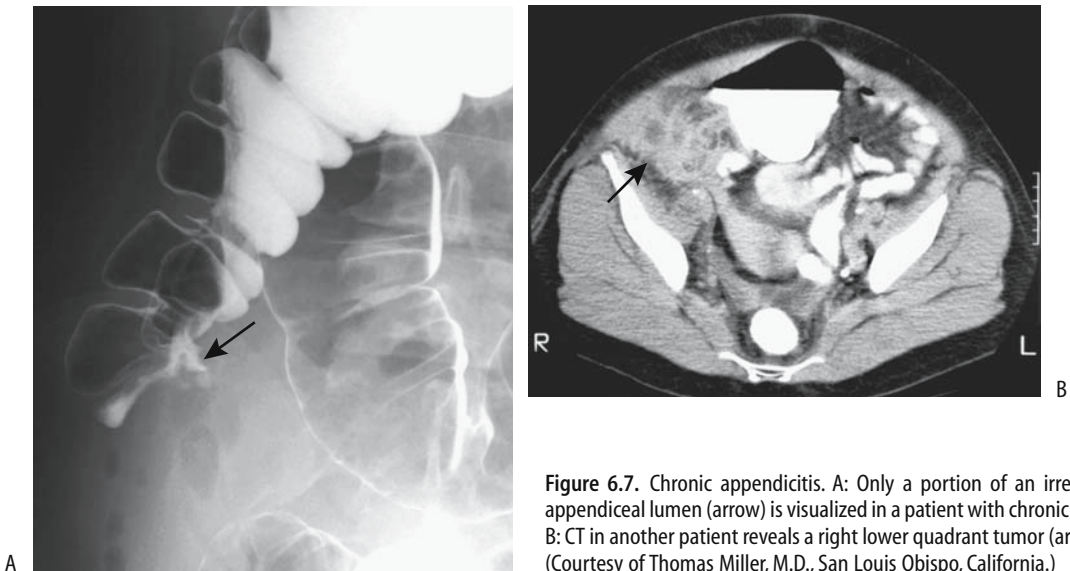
Chronic appendicitis. A: Only a portion of an irregular appendiceal lumen (arrow) is visualized in a patient with chronic pain. B: CT in another patient reveals a right lower quadrant tumor (arrow). (Courtesy of Thomas Miller, M.D., San Luis Obispo, California.)
